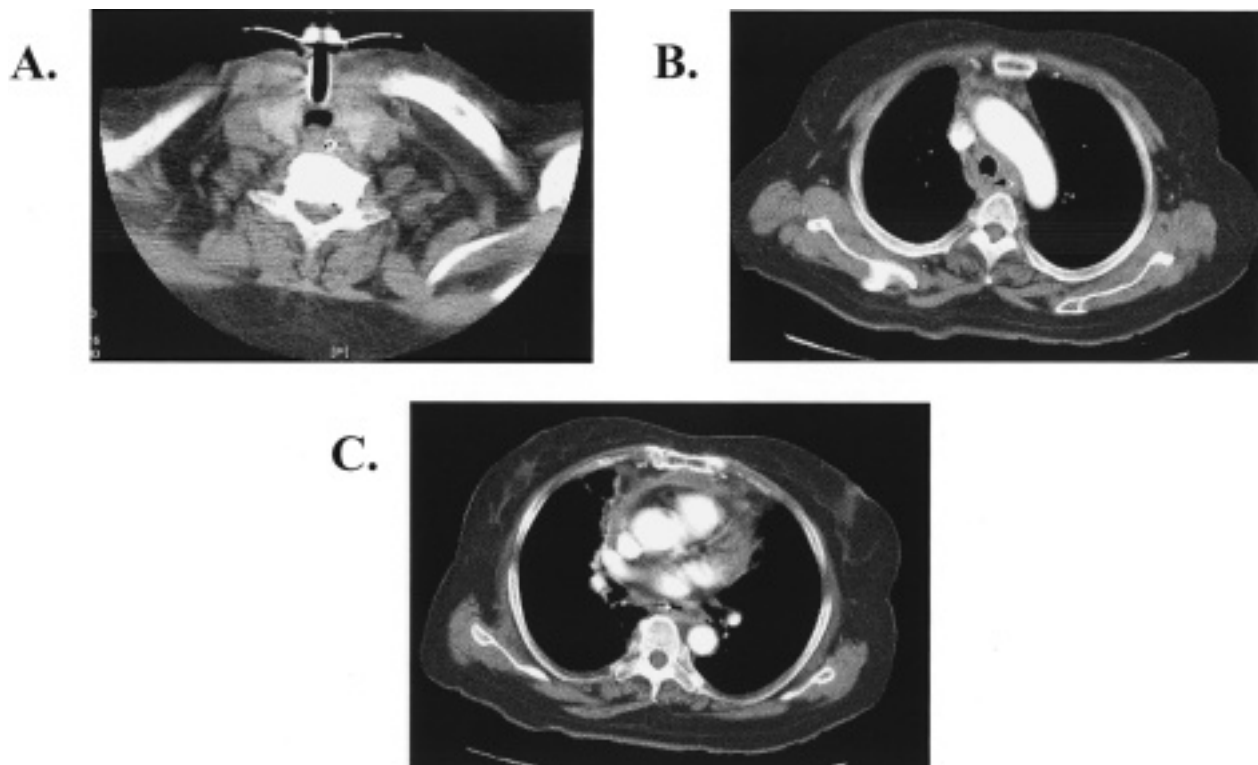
CT from neck to chest at postoperative day 21. Abscess in neck and anterior mediastinum was almost disappeared.
